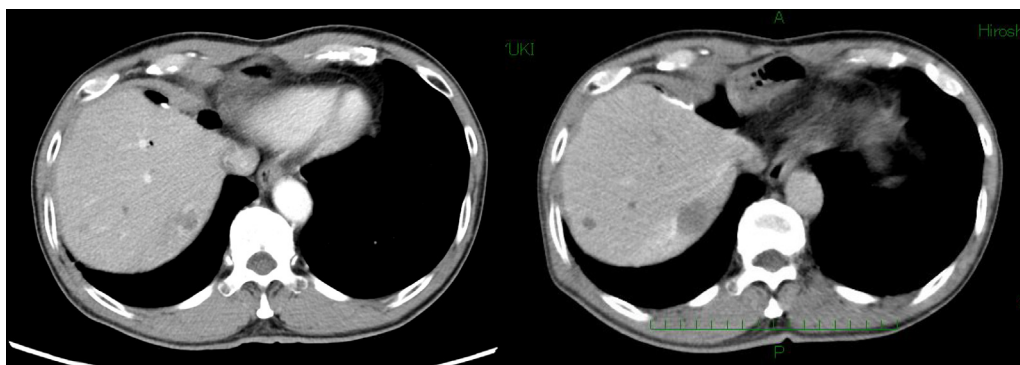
Abdominal computed tomography scans.
